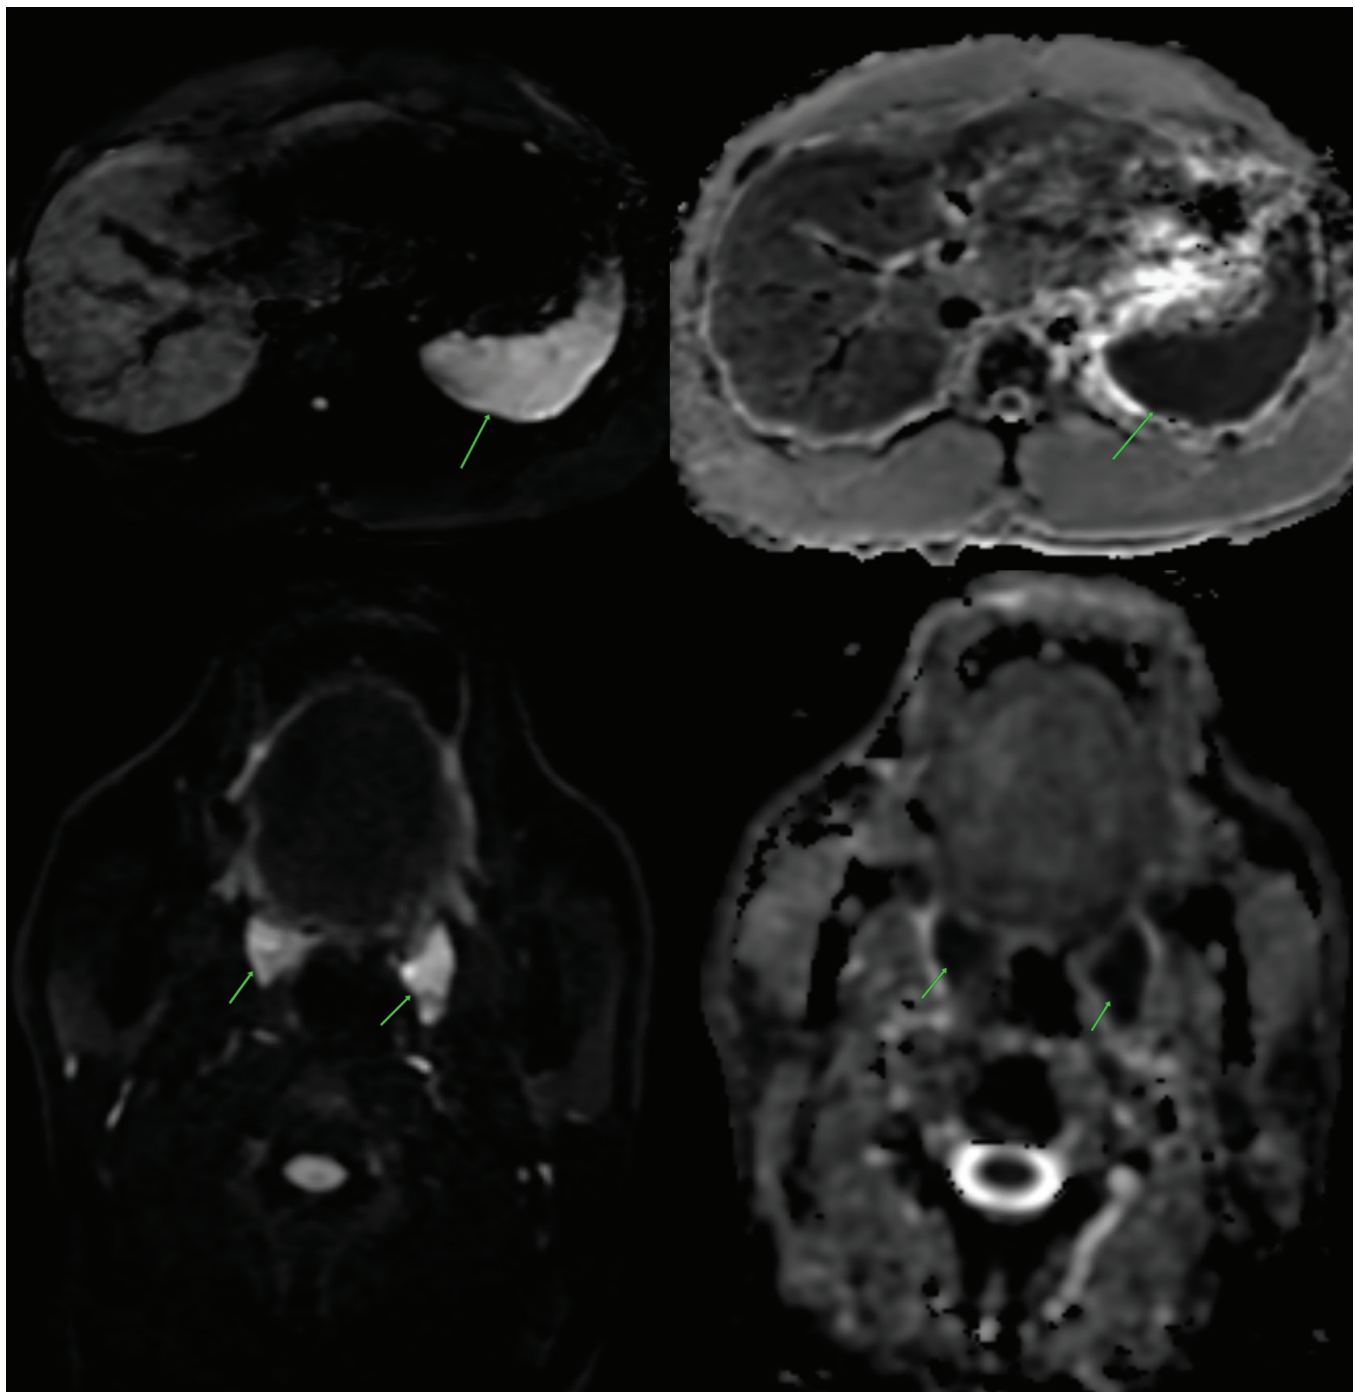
Images show physiological homogeneous diffusion restriction on DWI images and ADC map in normal spleen (marked with arrows at the top) and palatine tonsils (marked with arrows at the bottom)
